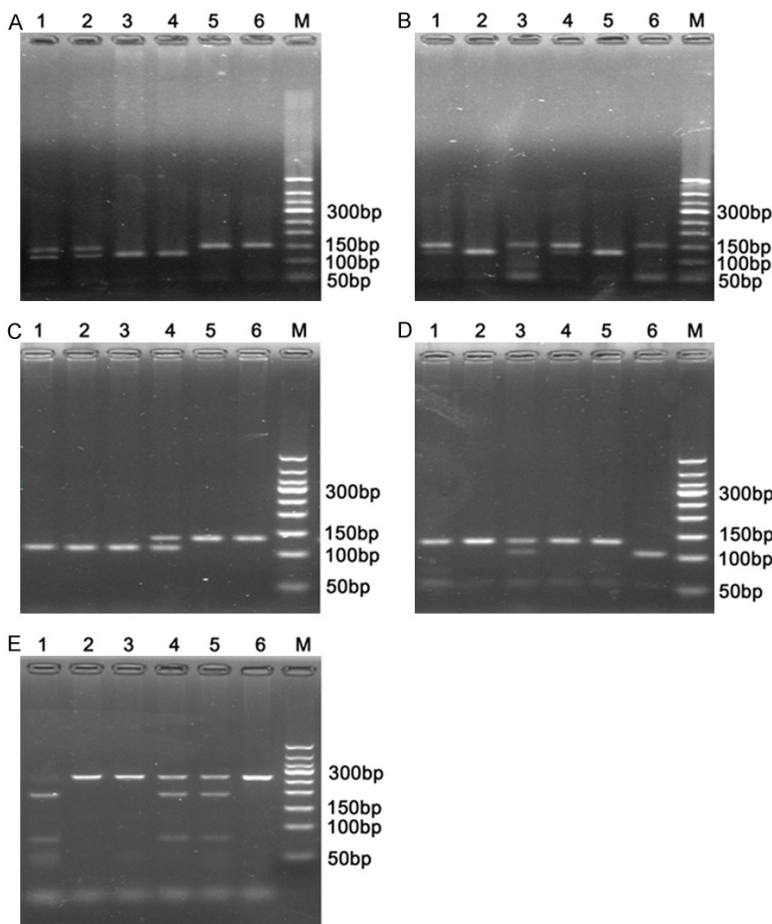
Gel confirmation of TNF- α gene promoter polymorphisms. PCR products were digested with restriction enzymes and separated on 3% polyacrylamide gels. A: rs361525 (-238): 1 & 2, GA; 3 & 4, GG; 5 & 6, AA; B: rs1800629 (-308): 1 & 4, GA; 2 & 5, GG; 3 & 6, AA; C: rs1799724 (-857): 1-3 CC; 4 CT; 5 & 6 TT; D: rs1800630 (-863): 1, 2, 4 & 5, CC; 3, CA; 6, AA; E: rs1799964 (-1031): 1, CC; 2, 3 & 6 TT; 4 & 5 TC. M, marker.
